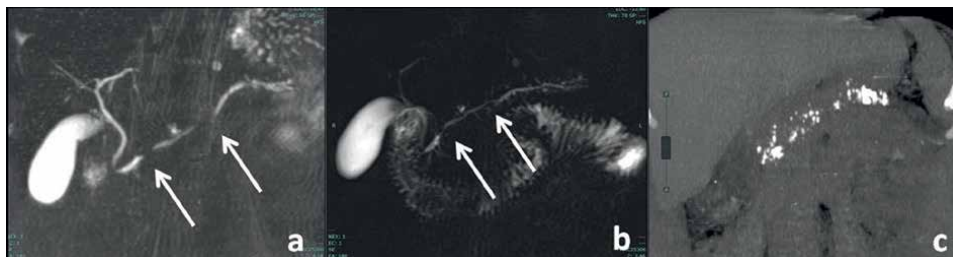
M, 65 yo. CP with evidence of two ductal strictures at MRCP sequences (arrows) at diagnosis (a) and a few months later (b). CT (c) performed two years later discovers multiple gross calcifications of pancreatic parenchyma, typical of CP.
